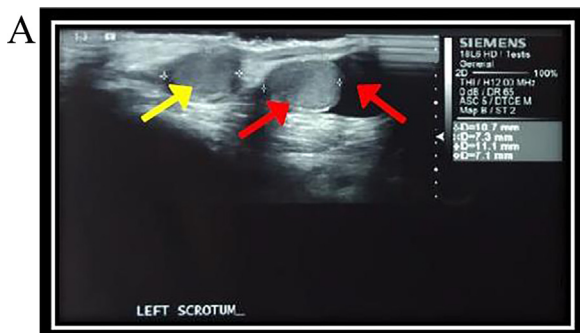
(a) Ultrasonography (b) Magnetic resonance image.
